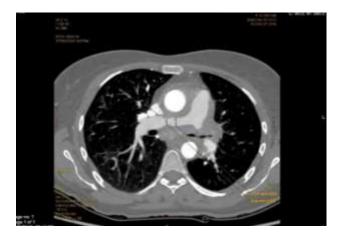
A CT chest with contrast showing a significant inflammatory process identified in the mediastinum surrounding the great vessels as well as significant narrowing of the left main stem bronchus as well as at least 40% narrowing of the right main pulmonary artery identified.
